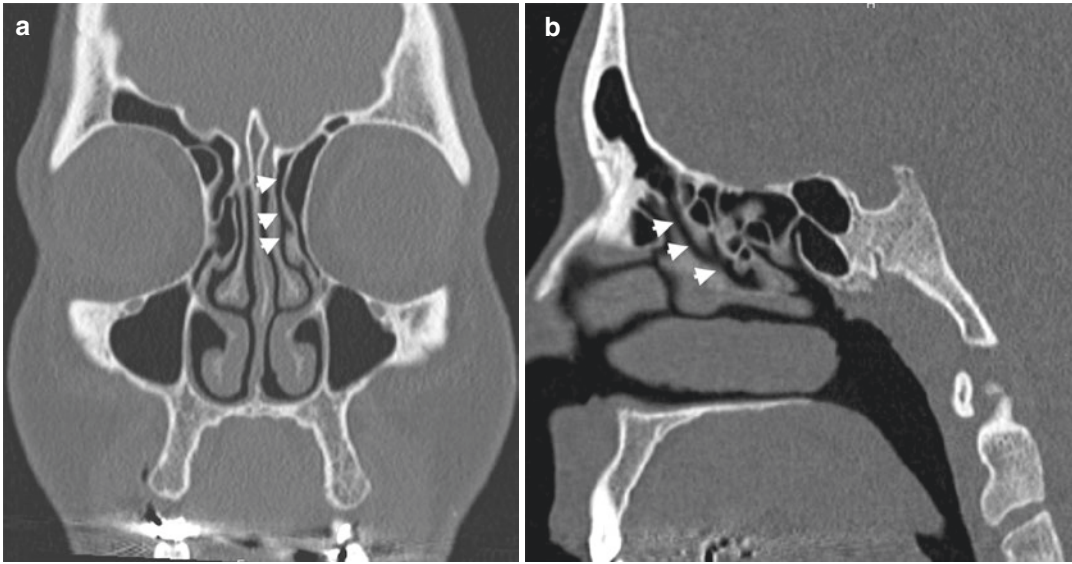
Coronal (a) and sagittal (b) CT images demonstrate nasofrontal duct (arrowheads) extending from frontal sinus to the middle meatus
